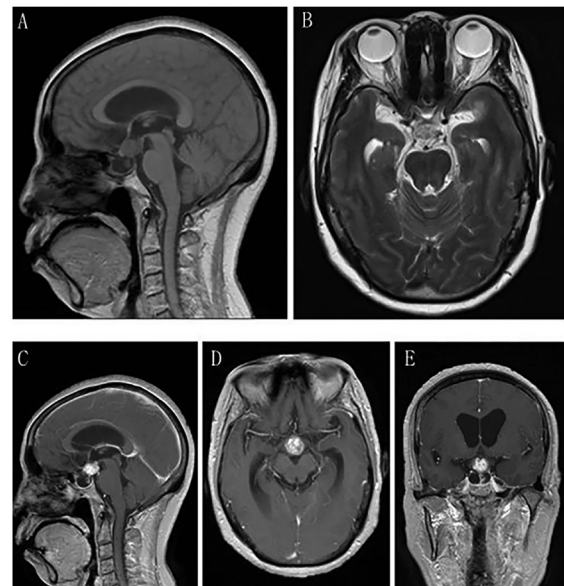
(A and B) On MRI, the mass was irregularly defined, with a cyst-solid intra- and suprasellar cystic lesion expansively growing into the third ventricle, and indicated to be (A) isointense on T1 and (B) hyperintense on T2. The optic nerve, optic chiasma and pituitary stalk were obviously displaced under compression. (C) Sagittal, (D) axial and (E) coronal images of enhanced MRI; the enhancement was inhomogeneous.
